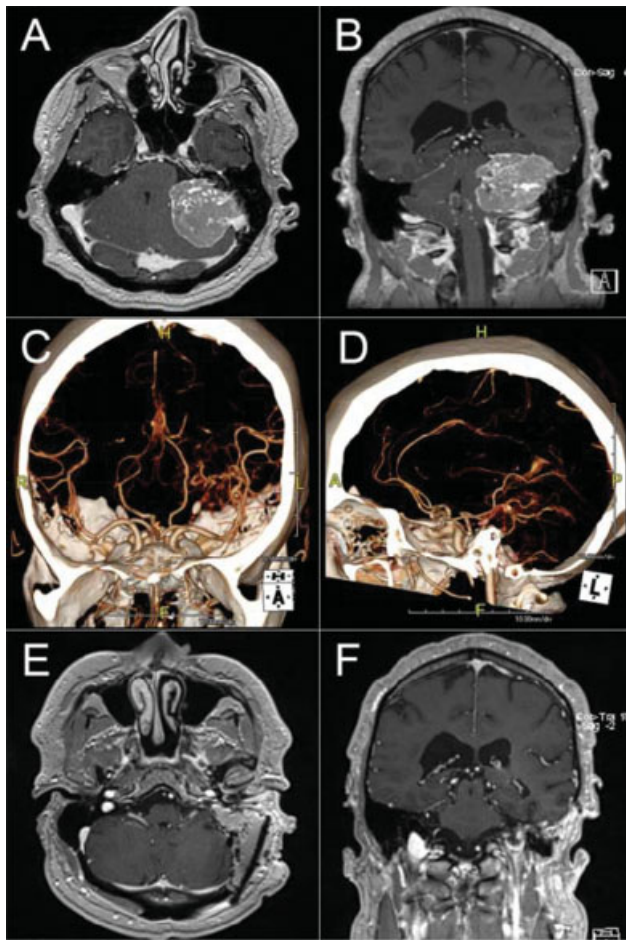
MRI T1 weighted Post contrast imaging showing Left CPA hyperintense lesion on axial (A) and Coronal (B) sections. CT angiogram (C and D) showed hyper-vascular lesion on the left side. MRI T1 weighted Post contrast imaging axial (E) and coronal (F) sections after two staged operation and completion of radiotherapy.
